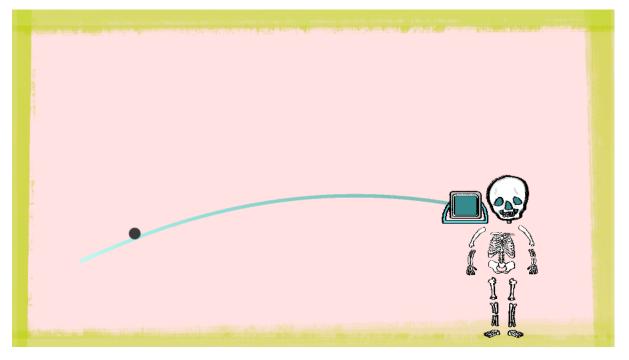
X-Ray mini-game.
